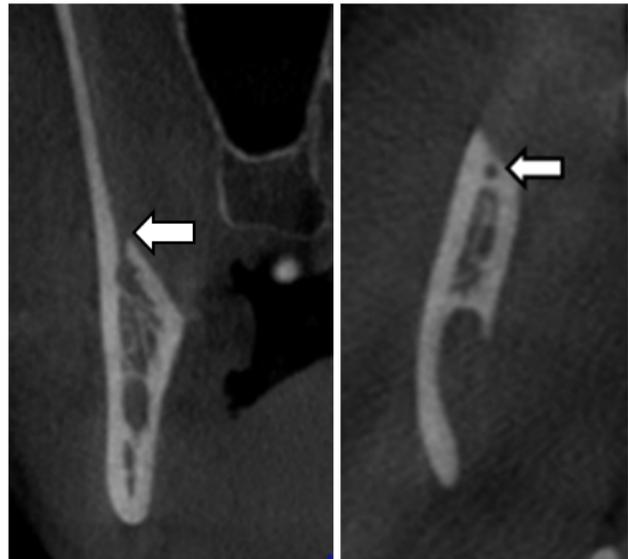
Sagittal and axial sections of CBCT showing retromolar canal type C
